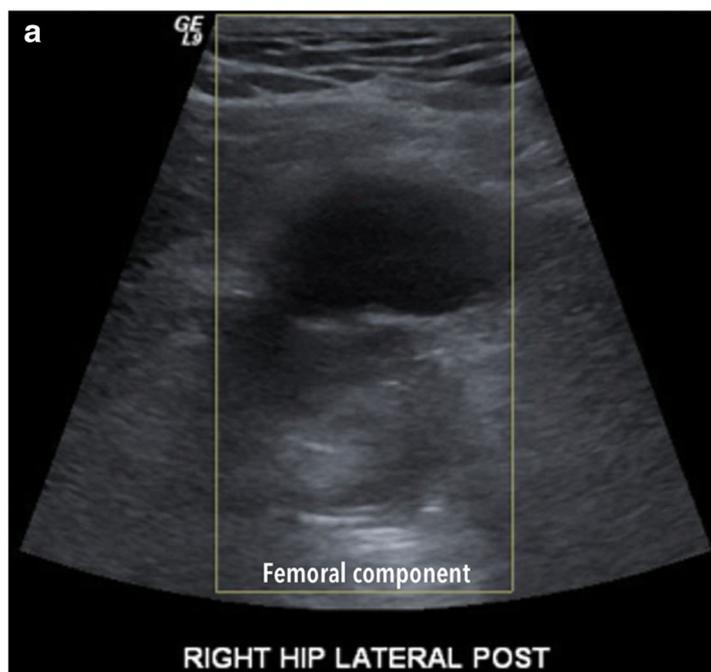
A 57-year-old asymptomatic male with a metal-on-metal right total hip arthroplasty with a complex solid-appearing pseudotumor at the posterior joint capsule. Grayscale sonographic image at the lateral aspect of the joint shows a
